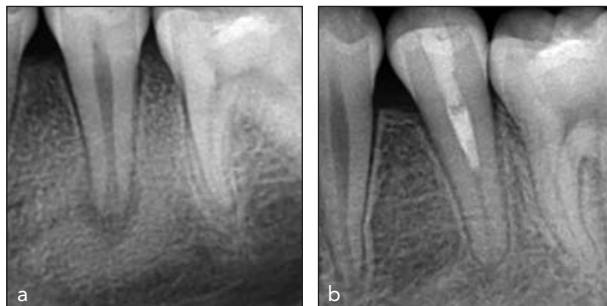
Successful regenerative endodontic therapy. (a) Preoperative view. (b) Follow-up radiograph taken 1 year postoperatively. An increase in root length and width as well as apical closure is evident in addition to the healing of the apical radiolucency.
